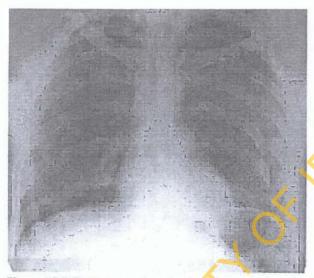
Postero-anterior chest radiograph showing multiple rib fractures with some ribs fractured in two places.
